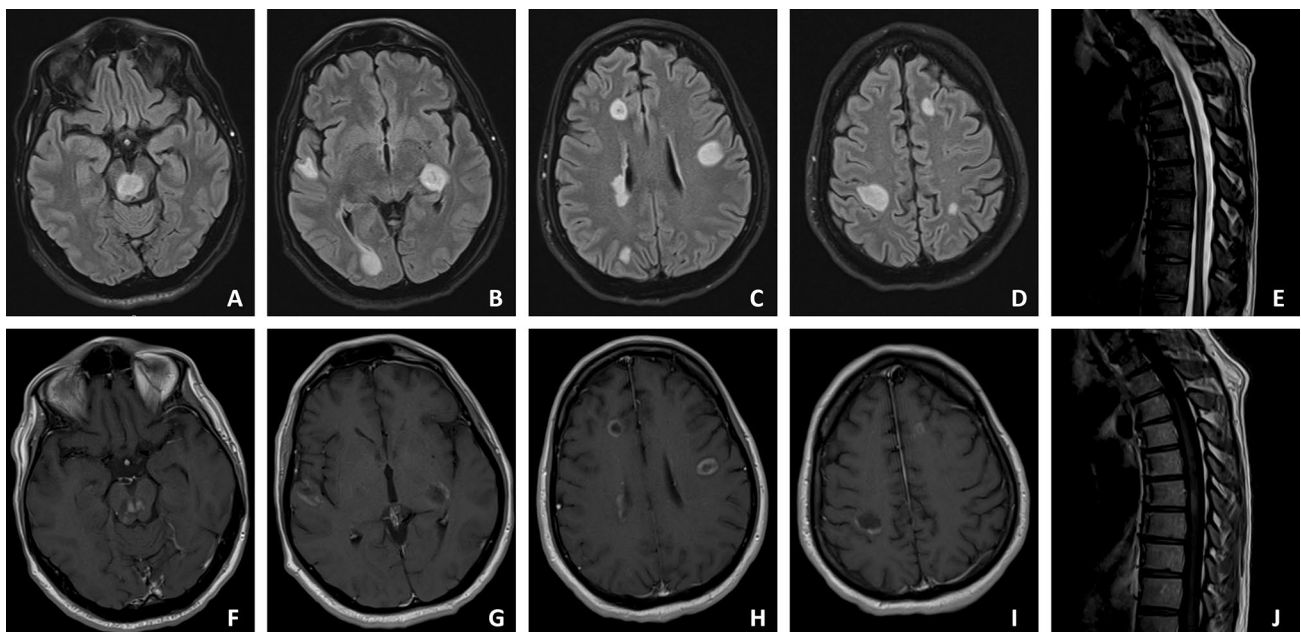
Brain and spinal cord MRI. Brain MRI showing supra- and infratentorial bilateral FLAIR-hyperintense white matter lesions suggestive of ADEM (A–D). In (E) spinal cord MRI documenting a
